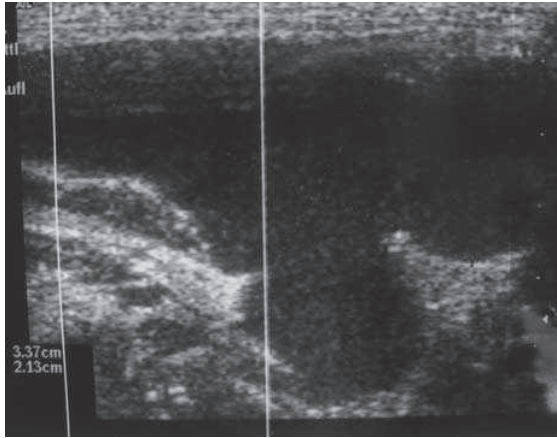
Ultrasound Finding
